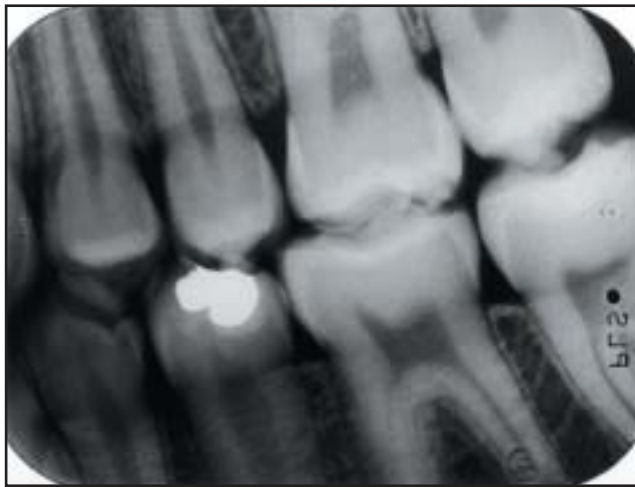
Bitewing radiograph taken eight months following amalgam placement. The tooth was asymptomatic. Reparative dentin formation may be observed under the restoration.
